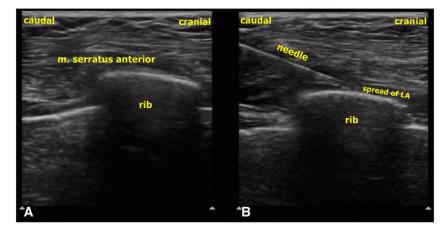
A) Sonographic anatomy of the serratus anterior plane block. The serratus anterior muscle and the rib are seen. B) Needle direction, craniocaudal spread of local anesthetic during serratus anterior plane block.
